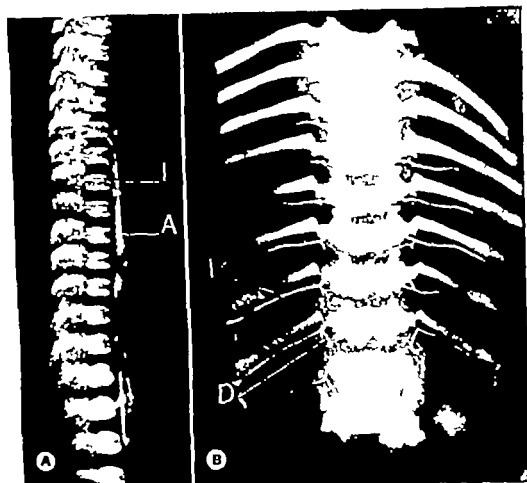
Full term fetal spinal column (99) A Lateral roentgenogram with opaque vascular injection of aorta notching of anterior surfaces of vertebral bodies diminished density of midportions longitudinal anastomosis of arteries in neural canal clearly visualized (A aorta I intercostal artery) B Anteroposterior view of same column after removal of aorta anastomosis of intercostal arteries and in complete ossification of cartilaginous neural ring (I intercostal artery D dorsal division of artery)
